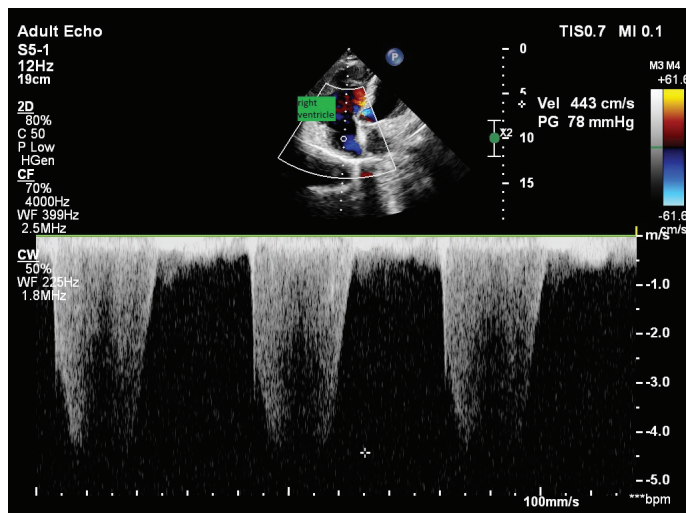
Doppler echocardiography demonstrating right-to-left shunts.
